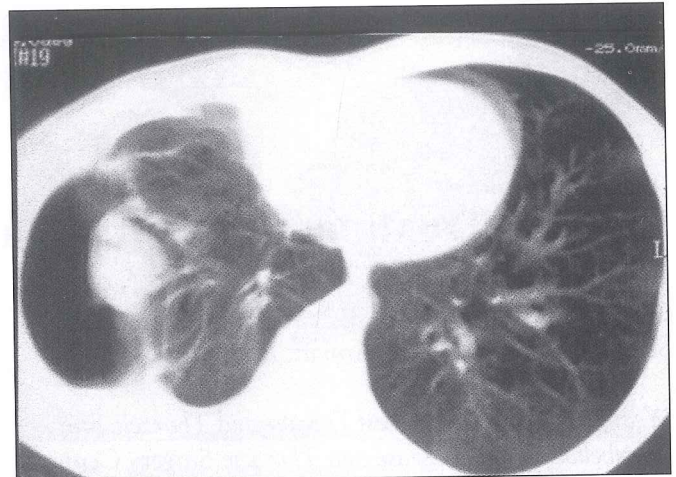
Chest CT of the same patient.
